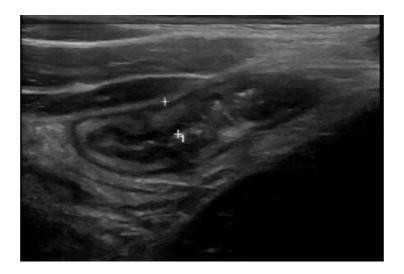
A transabdominal intestinal ultrasound image demonstrating an inflamed, thickened bowel wall of the terminal ileum in a pediatric patient with Crohn's disease.
